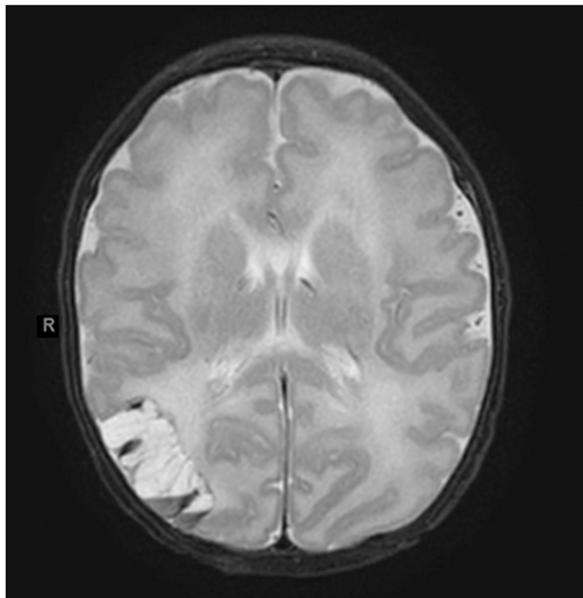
Magnetic resonance imaging of the brain showing a large area of encephalomalacia in the posterior right cerebral hemisphere, possibly related to a prior infarction.
